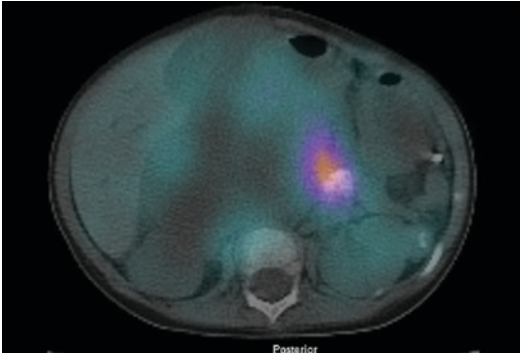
$^{123}\text{I}$ -mIBG SPECT/CT (a) of the abdomen in a 5-year-old boy with relapsed neuroblastoma, showing recurrent disease in an aorto-caval lymph node, which is clearly confirmed on subsequent MRI (b)
